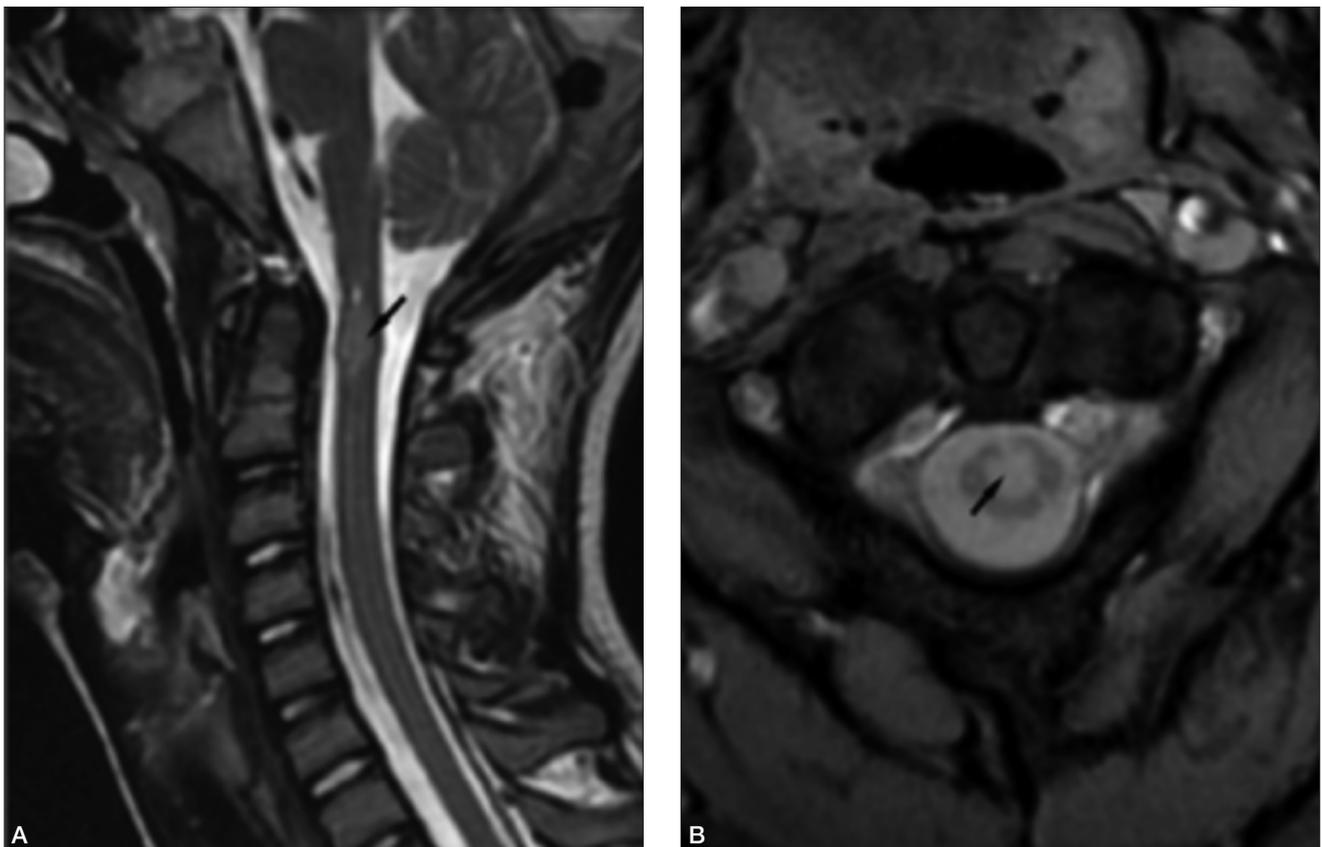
Sagittal (A) and axial (B) T2-weighted magnetic resonance images of the spinal cord in a child with NF2 showing round hyperintense lesions of the cervical cord at the C1 level (intraspinous ependymoma).
